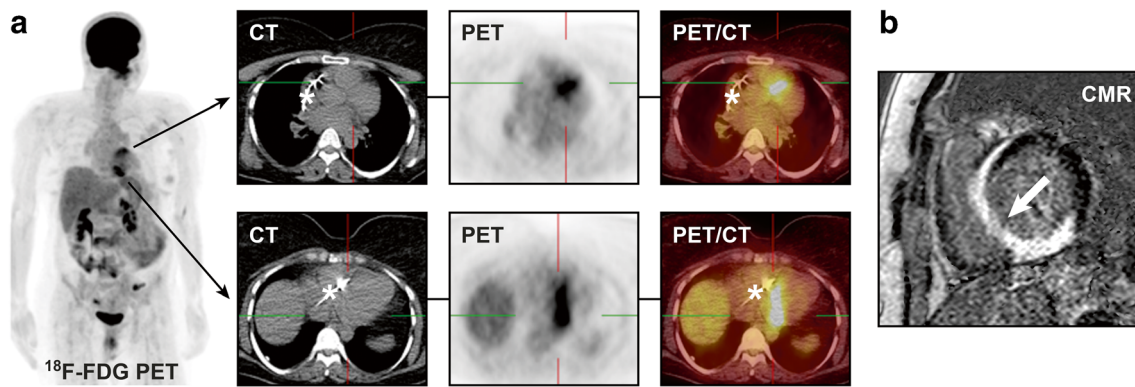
^{18}F -FDG PET for the assessment of cardiac sarcoidosis. In this patient with known sarcoidosis of the lungs, new-onset syncope and intermittent third-degree atrioventricular block, a cardiac PET study revealed an increased focal ^{18}F -FDG uptake in the septal and inferior wall segments, which is a finding consistent with an active cardiac
